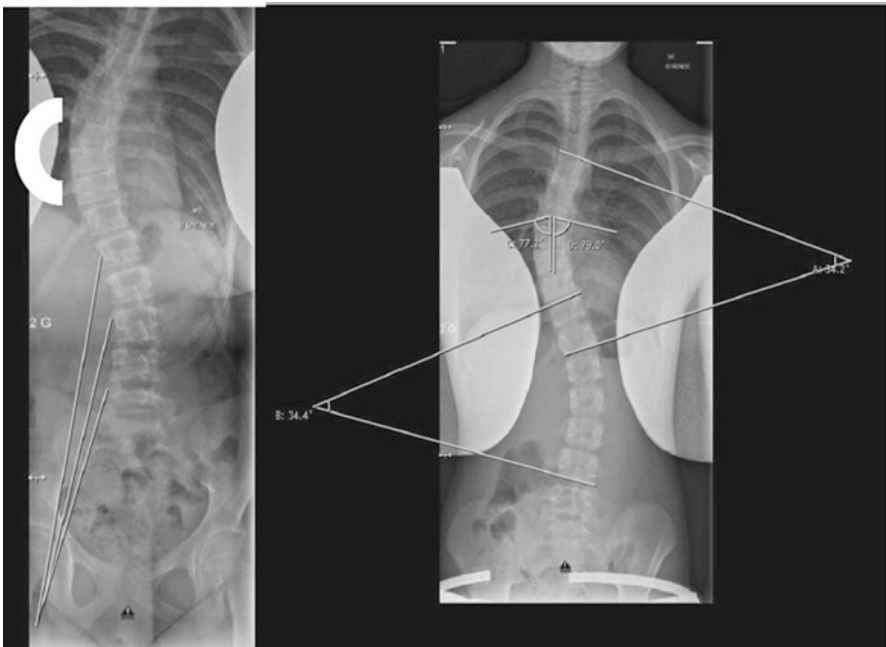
Radiographic image of scoliosis depicting the psoas major on the concave side of a thoracic scoliosis; the stronger thoracic muscles are marked with C and are located in the convex side of the scoliosis (left). Measurements of thoracic and lumbar Cobb's angle and concave and convex rib vertebral angle (right). (Original figure is reprinted from Wong et al. [44], which has been made available under Creative Commons Attribution <http://creativecommons.org/licenses/by/4.0/>, <http://creativecommons.org/publicdomain/zero/1.0/>)
